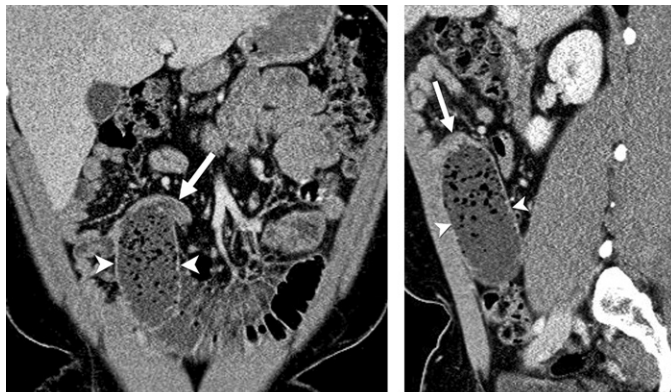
Stricture without imaging findings of active inflammation. Coronal (a) and sagittal (b) contrast-enhanced CT enterographic images with neutral oral contrast material in a patient with Crohn disease show a short segment with luminal narrowing and mild wall thickening in the mid jejunum (arrow) without mural hyperenhancement or mesenteric inflammatory changes. There is upstream small bowel dilation with fecalization of small bowel contents (arrowheads), a finding consistent with long-standing bowel stasis. The findings are consistent with a stricture without active inflammation.
